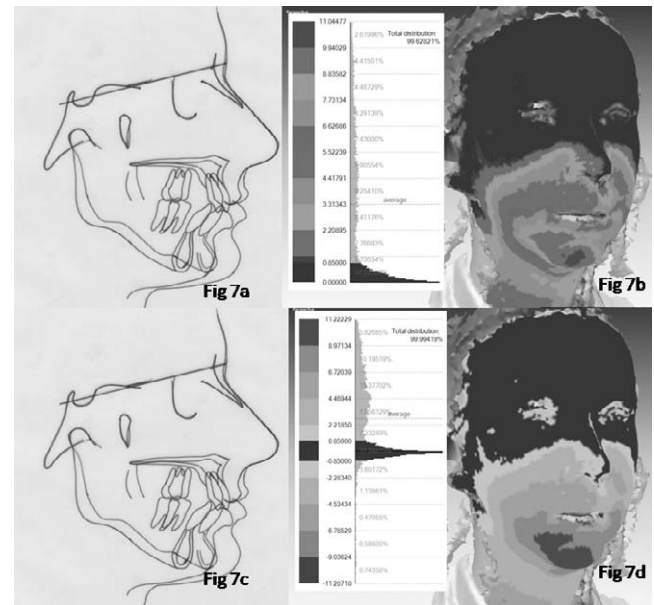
Subject H a) and c) Changes on the lateral cephalometric radiograph showed soft tissue changes. b) and d) The 3D superimposition revealed how the same landmarks moved forward.
